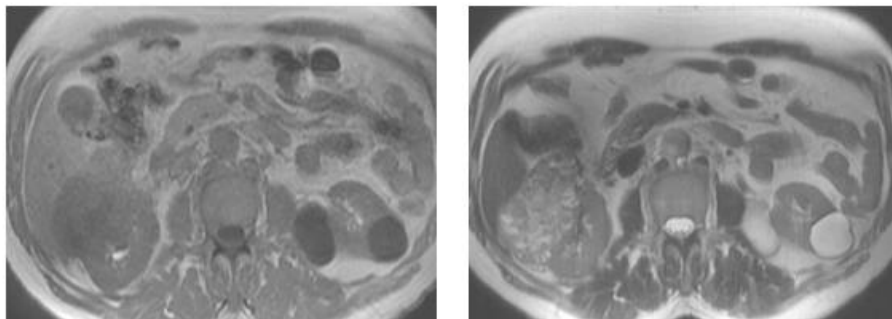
axial images of basic non enhanced MRI sequence including T1 and T2 , mass show low signal on T1 and high signal on T2
